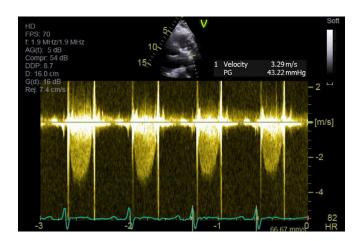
Continuous wave Doppler interrogation of the pulmonic valve after thrombolysis. Spectral Doppler depicting no pulmonic valve regurgitation, reduction in gradient, and restoration of "metallic click" Doppler signals at the beginning and end of systole.
